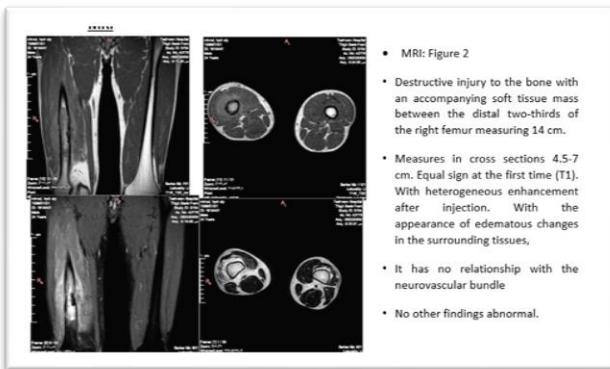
MRI of the femur
